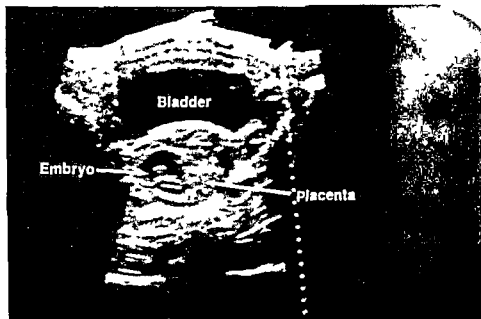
Sonogram (Transverse section) Intrauterine pregnancy one year after a hydatidiform mole
